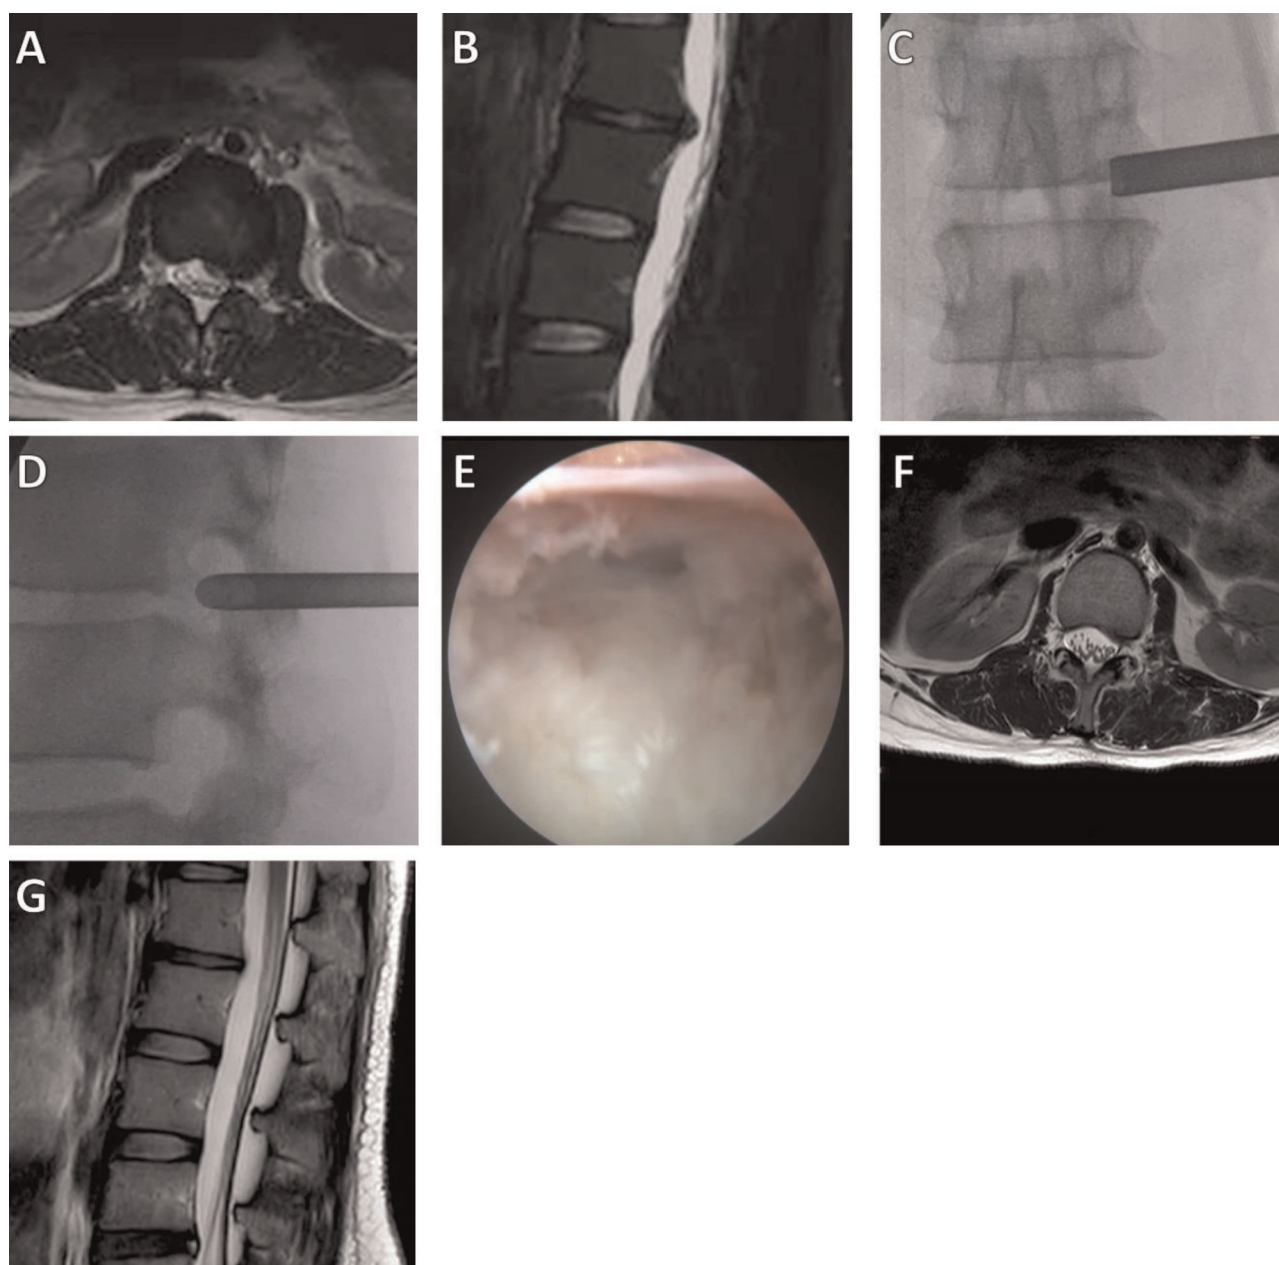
A 28-year-old female patient had radiating pain in the left lower extremity. (A,B) Preoperative axial and sagittal MRI results showed L1–2 LDH, with compression of the dural sac; (C,D) Intraoperative anteroposterior and lateral X-rays show the position of the working cannula; (E) The herniated intervertebral disc was removed, and the nerve root decompression was satisfactory; (F,G) Postoperative MRI showed that the herniated intervertebral disc resection was satisfactory.
